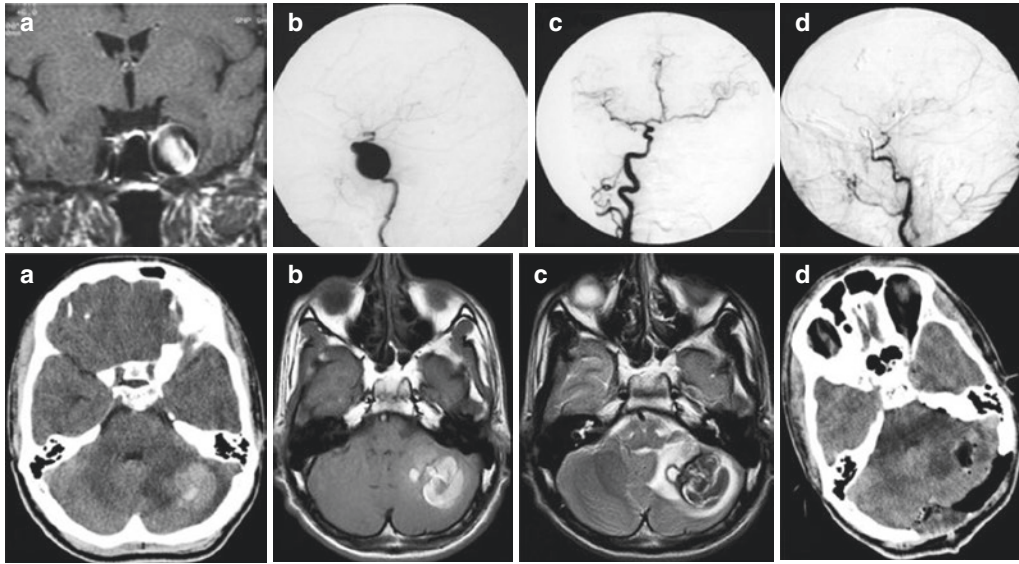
Top row:* Cavernous segment aneurysm of internal carotid artery in a 60-year-old man. The patient was admitted for 3 months with double vision. On neurological examination, there was restriction on the left side with ptosis and upward and downward gaze. Preoperative T1-weighted axial MRI with contrast (a) and DSAs (b, c) demonstrate cavernous segment aneurysm of the left internal carotid artery. The patient was operated under general anesthesia. Direct clipping was applied to the aneurysm. There were no problems after surgery. There is no aneurysm on postoperative DSA examination (d).
